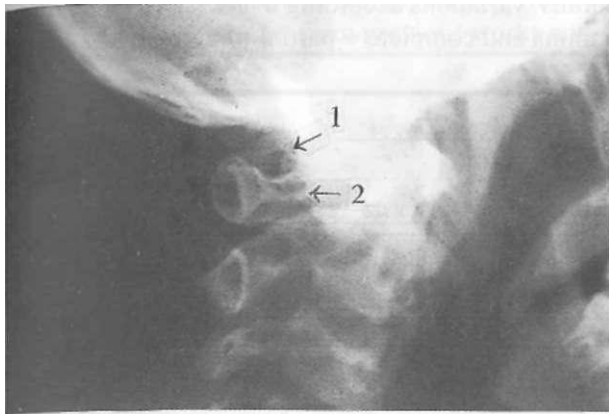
Thick type of complete foramen at lateral cervical x-ray (from right side) 1: complete foramen, 2: arcus posterior of atlas.
